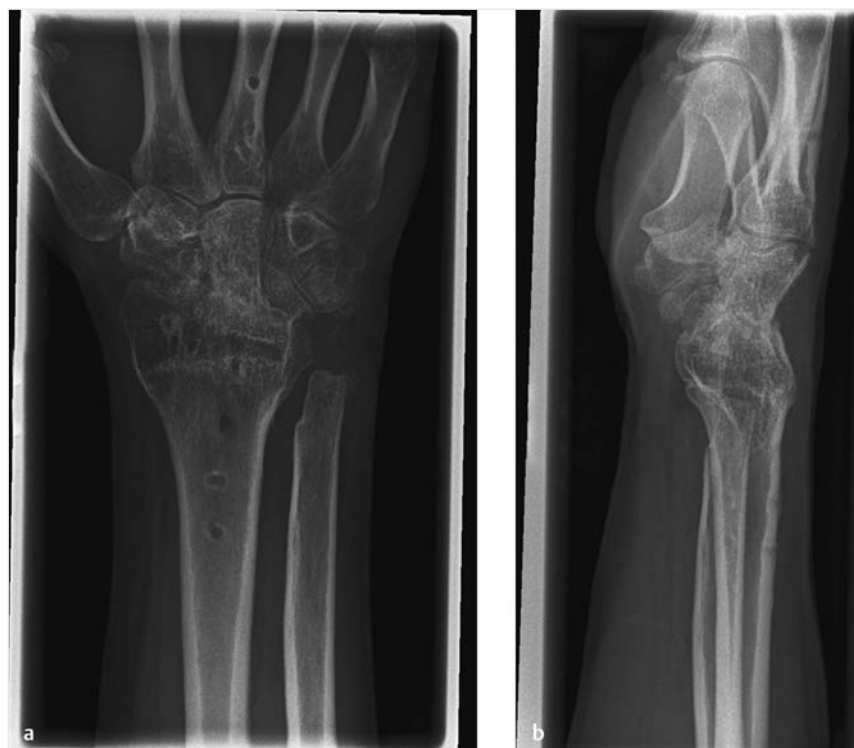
(a, b) X-ray images of the right wrist after total wrist fusion and partial ulnar head resection. At rest, the ulnar stump is in correct position.
